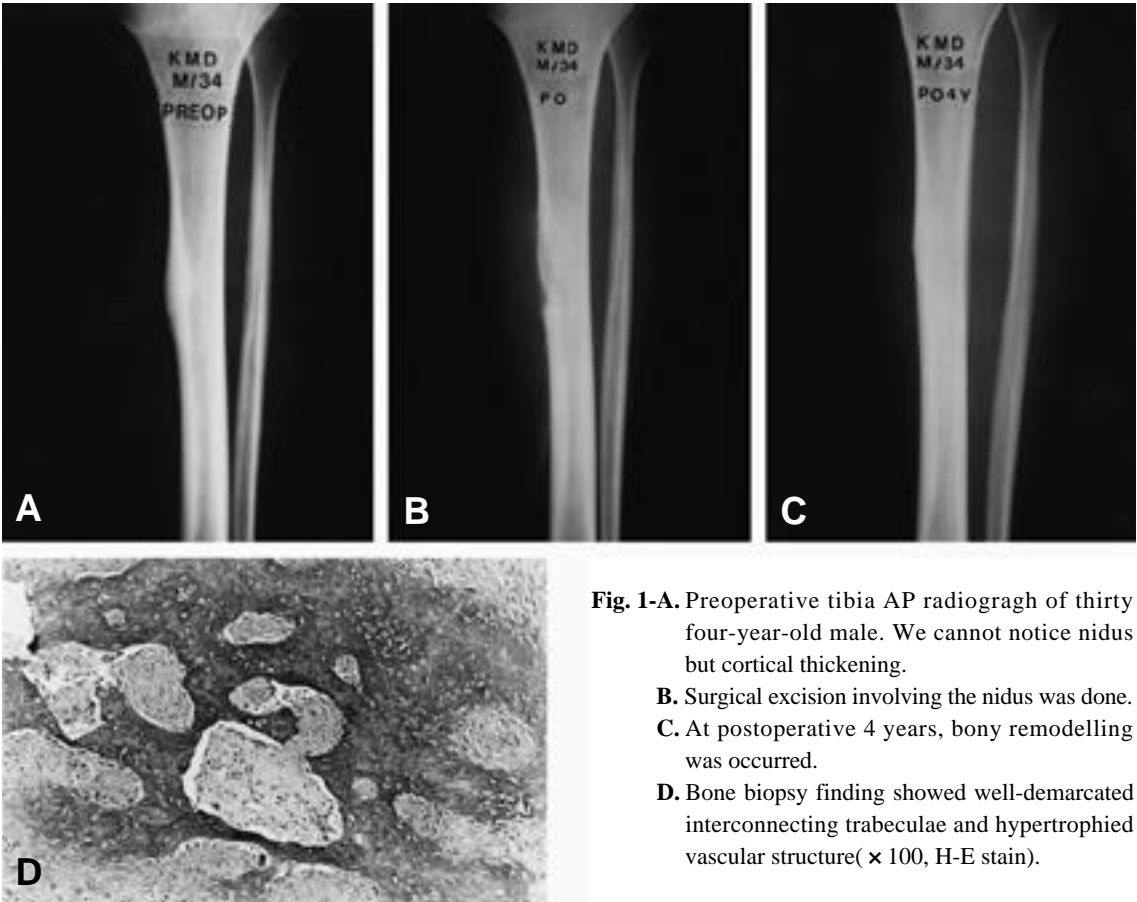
Preoperative tibia AP radiograph of thirty four-year-old male. We cannot notice nidus but cortical thickening.
